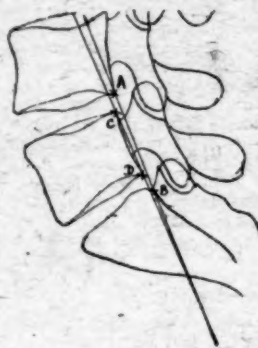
Tracing of a radiograph of a normal subject; the lines drawn intersect below the fifth lumbar vertebra.
